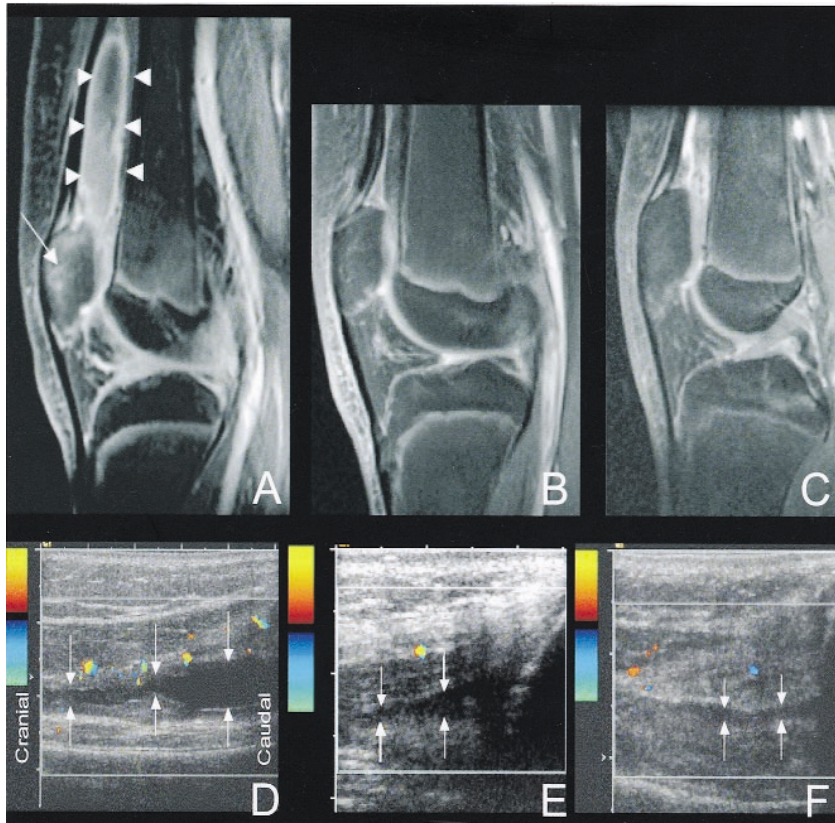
Panels A–C: sagittal fat-suppressed T1-weighted MR images of the left knee following contrast administration: (A) prior to, (B) at 6 weeks, and (C) 2 years after starting etanercept. At baseline (A), there is increased enhancement of the superior aspect of the patella (quadriceps tendon insertion, arrow) in keeping with enthesitis. The patellar enhancement (arrowheads in A) is distinctly better by 6 weeks (B) and fully normalized and sustained at 2 years (C). Sagittal color Doppler sonograms (D–F) of the suprapatellar bursa of the left knee were obtained (D) at baseline, (E) after 6 months, and (F) after 1 year of therapy. Moderate joint effusion (arrows) and synovial hyperemia (color pixels) are seen on the image acquired at baseline (D). A remarkable interval reduction in the amount of joint effusion (arrows) and synovial hyperemia is visible in subsequent ultrasound images obtained (E) after 6 months and (F) after 1 year of therapy. Panel D represents the superior and mid aspects of the suprapatellar bursa, panels E and F the inferior aspect of the bursa.
